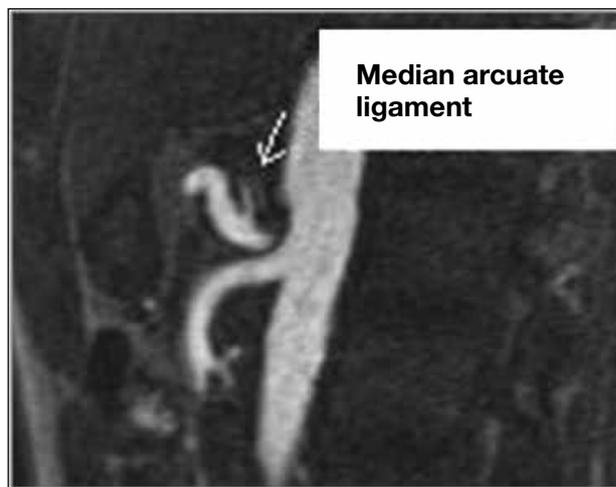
The median arcuate ligament can be seen in the magnetic resonance imaging in patient A.
